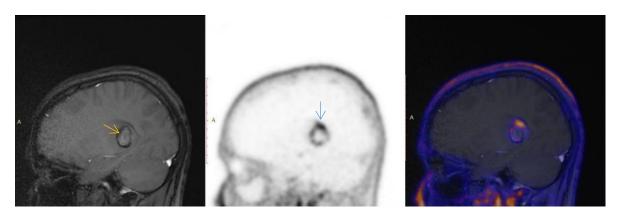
Left to right, sagittal T1 MRI with a post-biopsy haemorrhagic core (yellow arrow), F-Choline PET, and fused PET/MRI images in a patient with high grade glioma. Notice the high F-Choline uptake especially in the superior part of the tumour (blue arrow) with the negligible uptake by the normal brain tissue.
